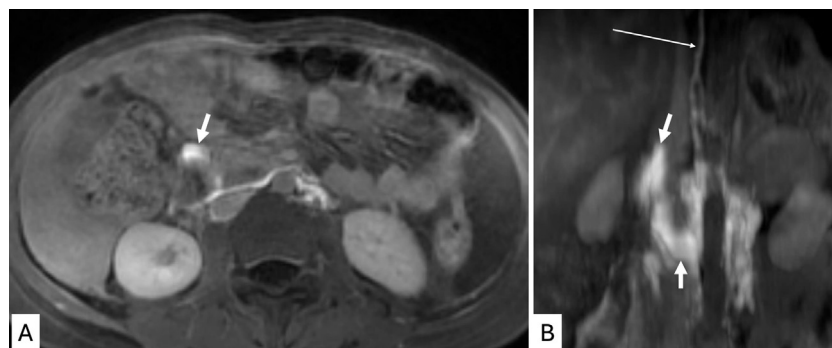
MRI lymphangiography. (A) Axial T1W fatsat sequence at the level of the kidneys shows extravasation of contrast at the level of the right renal hilum (short white arrow). (B) Coronal reformation of T1W sequence shows extravasation of contrast (short white arrows) with visualization of the lower thoracic duct (long white arrow).
